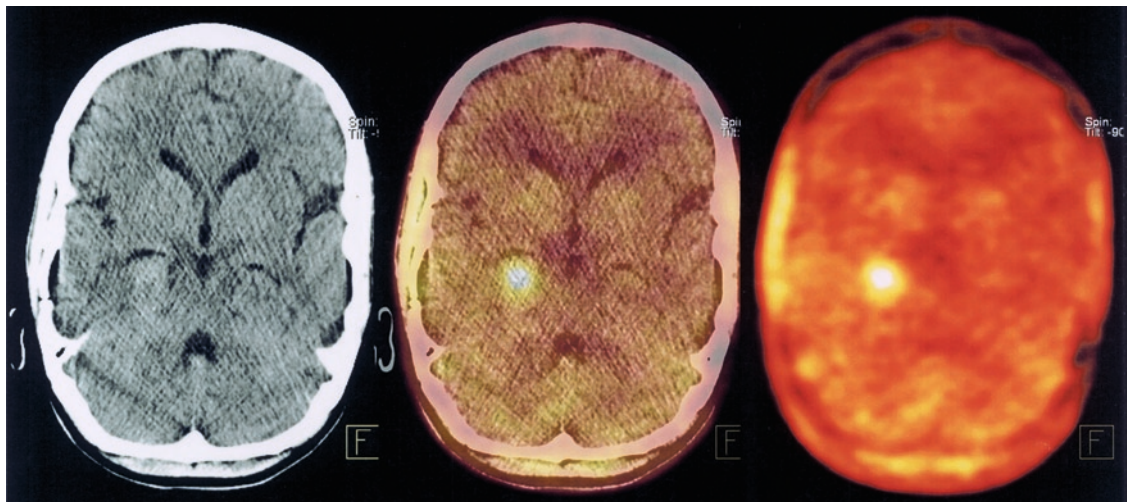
Twenty-five year old female patient with astrocytoma WHO II°. The FET PET-CT study was done 15 days after surgery. Patient positioning was done using a special flat bed and a thermoplastic head mask for reproducible positioning. Residual tumor is delineated by FET uptake (*right*), image fusion (*middle*) with the radiotherapy planning CT (*left*) allows for inclusion of the metabolic information in the definition of target volumes
